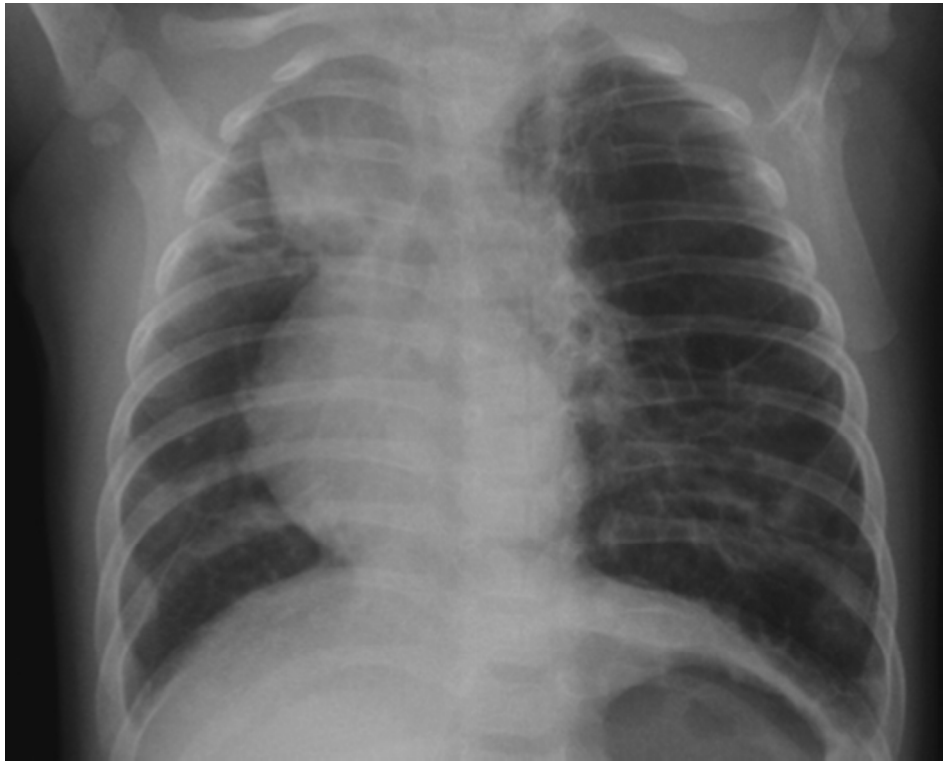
Chest radiograph of case 1 at age 3 months demonstrating hyperinflation and lucency within the left lung with mediastinal shift to the right. Fine interstitial thickening and septations are noted in the left lower zone. There is right upper lobe consolidation.
